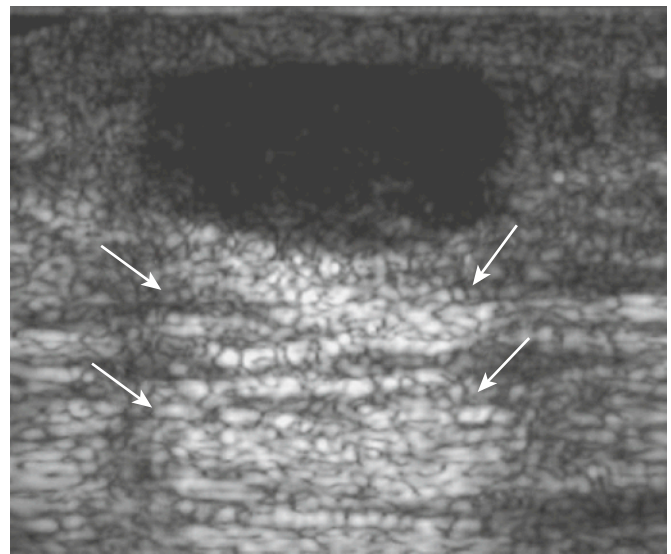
Acoustic enhancement (*arrows*) can be seen when a fluid-content structure transmits ultrasound with a velocity different from that of the surrounding tissue. The center of the mass is characterized by low signal intensity.
